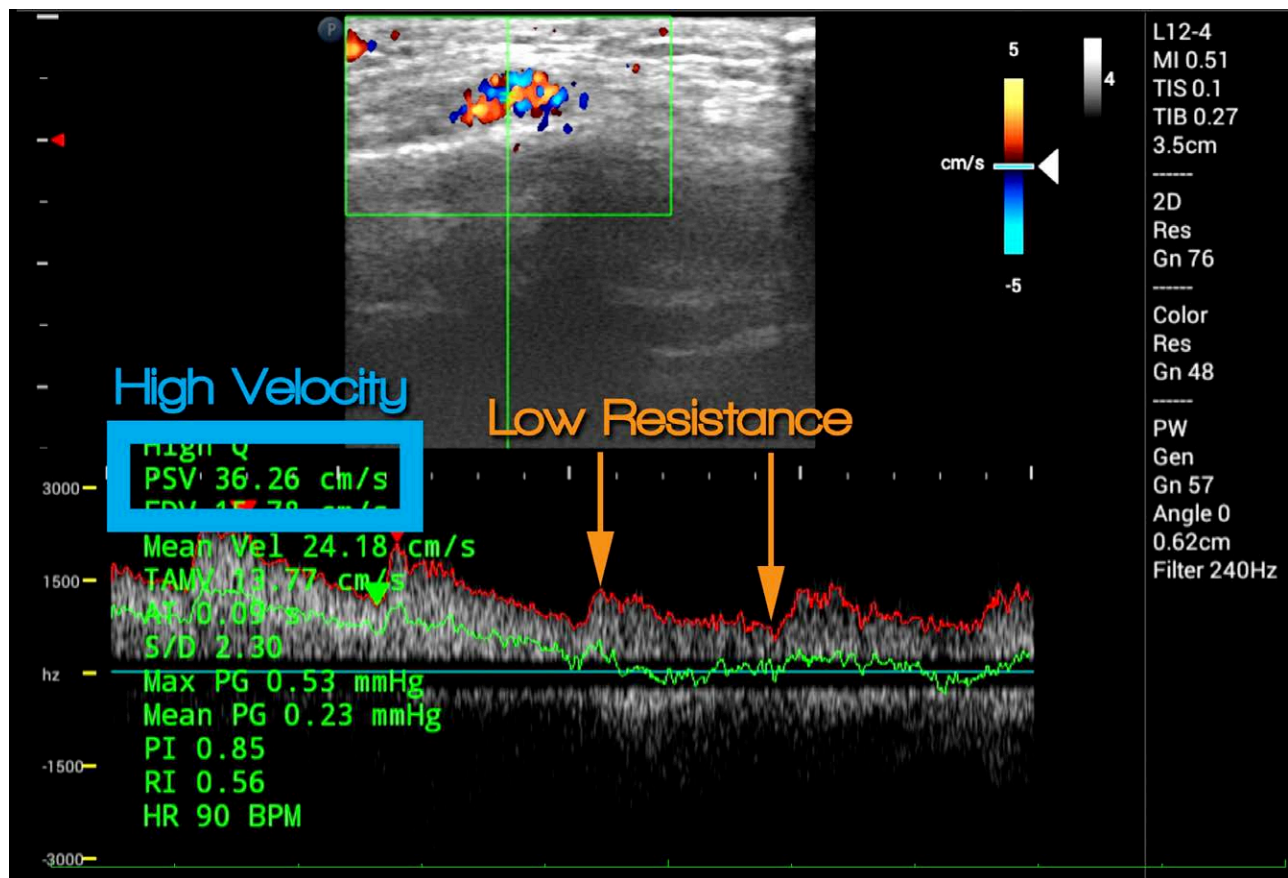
Typical power Doppler of AVM. The shape and absolute values show a high velocity flow (cyan square and arrow) and a low resistance shape (orange arrows). AVM indicates arteriovenous malformation.
